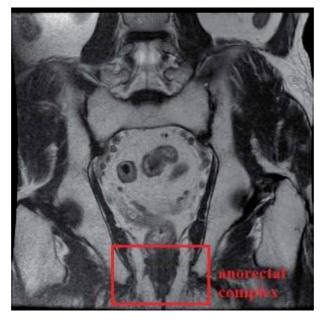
Anorectal complex (coronal T₂ weighted MR image).
